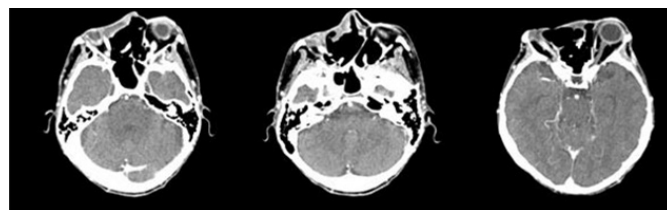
Head and maxillofacial computed tomography (CT) scan after four months the start of sonidegib therapy.
